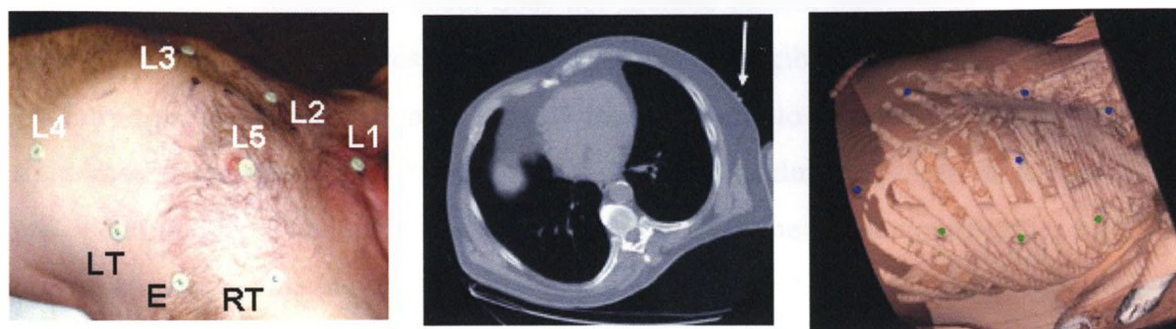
Pre-operative fiducial markers and port placement on a patient. *Left:* Patient on the CT patient bed with fiducial markers placed at each of the five landmarks and at the three expert chosen port placement sites. *Centre:* CT slice of the patient tilted on a towel – as in surgery – with the arrow pointing to the CT-visible landmark. *Right:* Skin and rib reconstructions showing the landmarks (*blue*) and the port positions (*green*).
